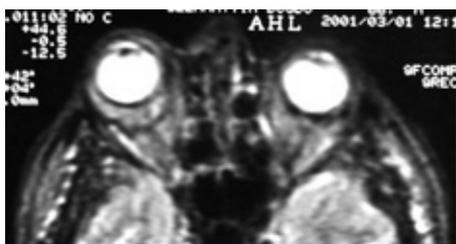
On MRI the right eye is exophthalmic, and the globe wall is thickened diffusely (posterior wall 10 mm). There is no rectus muscle or optic nerve involvement.
